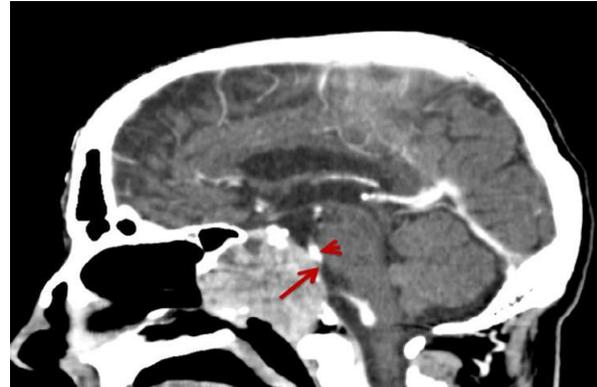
Sagittal contrast-enhanced CT image in which tumoral invasion of prepontine cistern (arrow) with basilar artery compression (arrowhead) is seen (Turliuc *et al.*,2016c).
